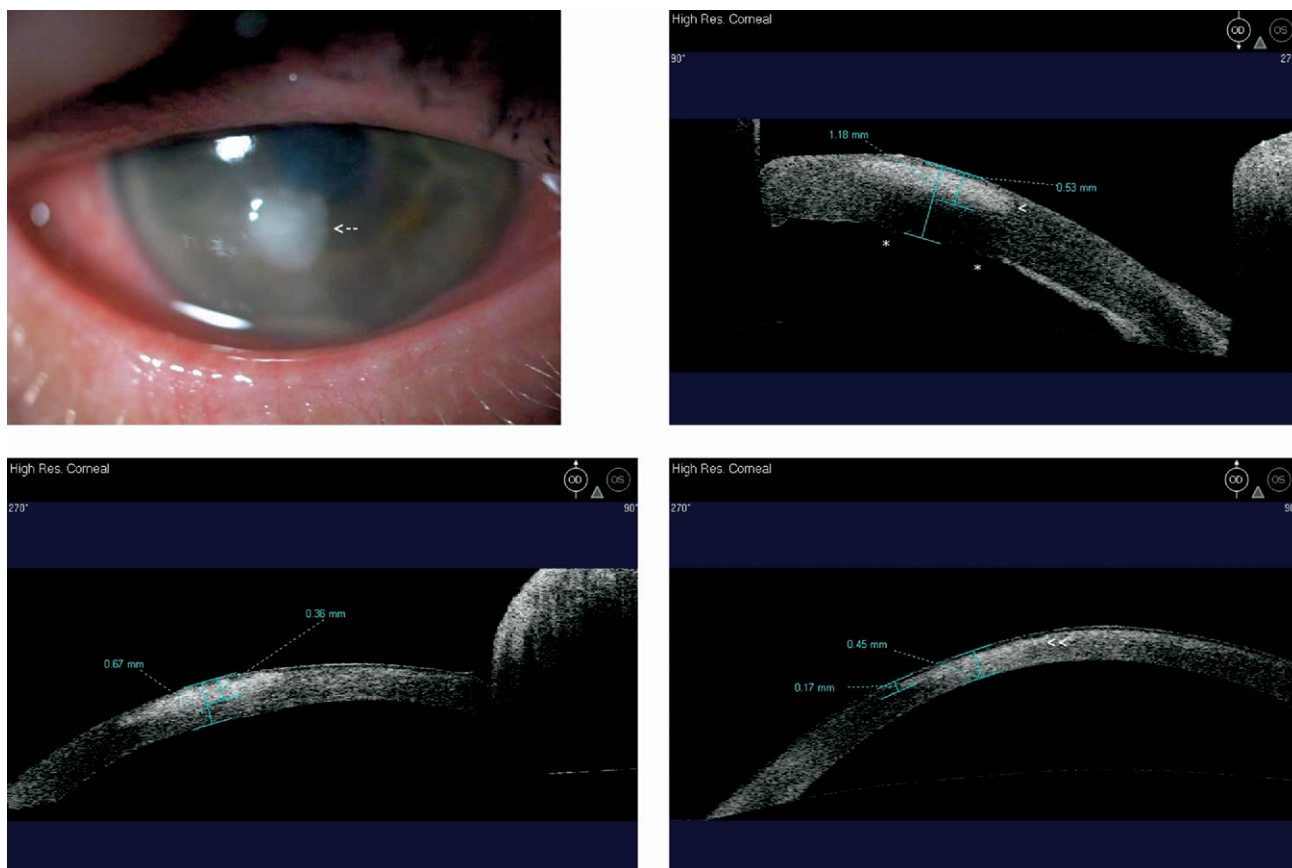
Images demonstrating microbial keratitis in a contact lens wearer, including serial high-resolution AS OCT images at the 90-degree meridian. (Top left) Anterior segment photograph obtained at presentation showing corneal infiltrate (arrow). (Top right) AS OCT image obtained at presentation showing an epithelial defect and a thick stromal infiltrate (<). Descemet folds (*) are present because of associated edema. (Bottom left) AS OCT image obtained two weeks after presentation showing reduction of infiltrate and CT with a smoother endothelial surface. (Bottom right) AS OCT image obtained eight weeks after presentation showing further reduction of CT and anterior stromal scarring (<<).
